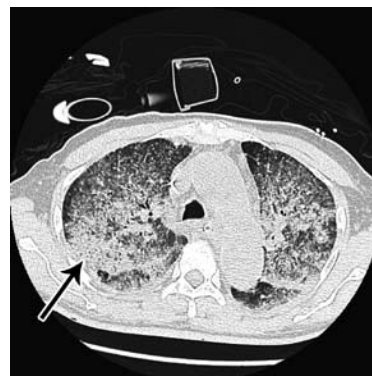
Chest CT scan showing diffuse bilateral lung nodularity and airspace consolidation (arrow).
